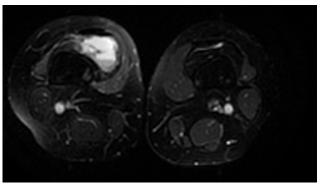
Axial T_2 -weighted magnetic resonance imaging of thighs shows ganglion cyst just distal to vastus medialis within suprapatellar pouch.
